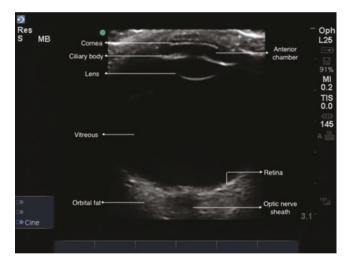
Ocular ultrasound with normal anatomy findings with anatomy labeled
